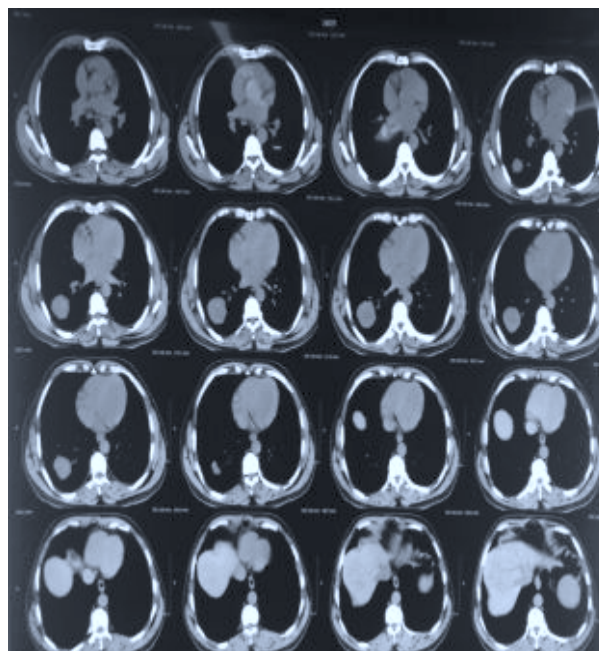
CT Scan Mediastinal view
